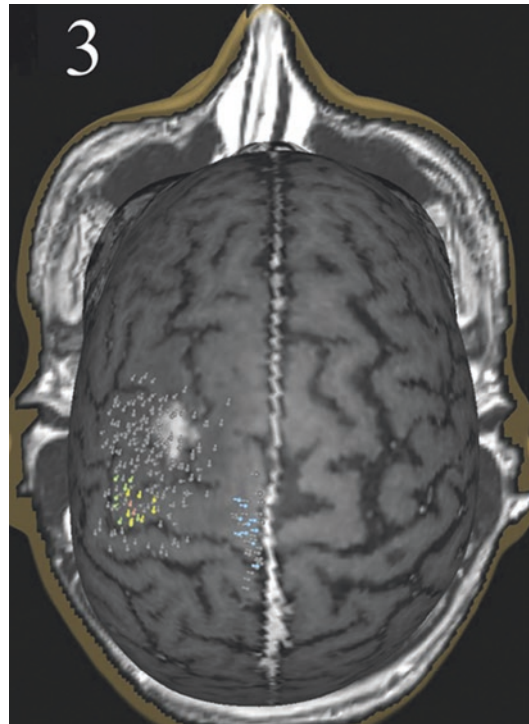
nTMS somatotopic mapping for a rolandic tumour patient (patient #3). Each stimuli point is coloured according to the EMG channel with the highest amplitude MEP output. The peeling depth of the 3D magnetic resonance imaging was set to 25 mm to visualize the tumour (red arrow) with the central sulcus. Green, abductor pollicis brevis; yellow, abductor digiti minimi; pink, first dorsal interosseus; blue, tibialis anterior; grey, no response. (Original figure obtained from Picht et al. [152], with permission from Oxford University Press)
